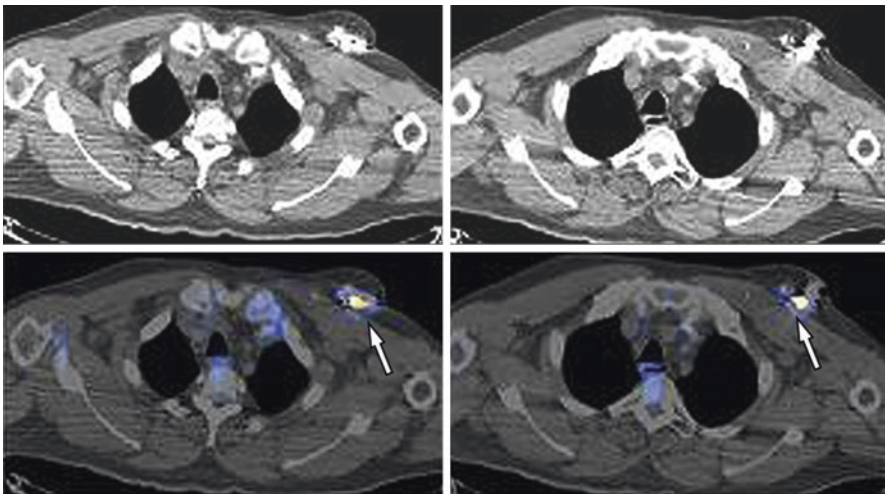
Labeled white blood cell SPET/CT for CIEDI. Technetium-99 hexamethylpropyleneamine oxime-labeled autologous white blood cell ($^{99\text{m}}\text{Tc}$ -HMPAO-WBC) scintigraphy in a patient with a suspect of CIED infection, which shows a localized pocket involvement at SPECT/CT fusion imaging (lower images; upper images show CT scan alone of the same patient). (Reproduced from Erba et al. [45] with permission)
